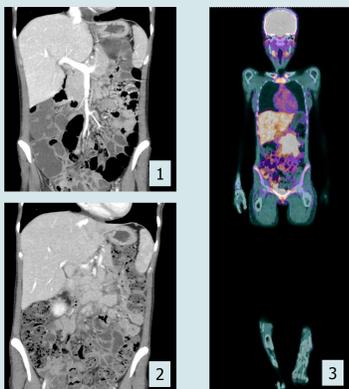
Rapid development of coalescing mesenteric lymph nodes seen on CT abdomen and pelvis 3 June (Fig.1) and 27 June 2017 (Fig.2).
